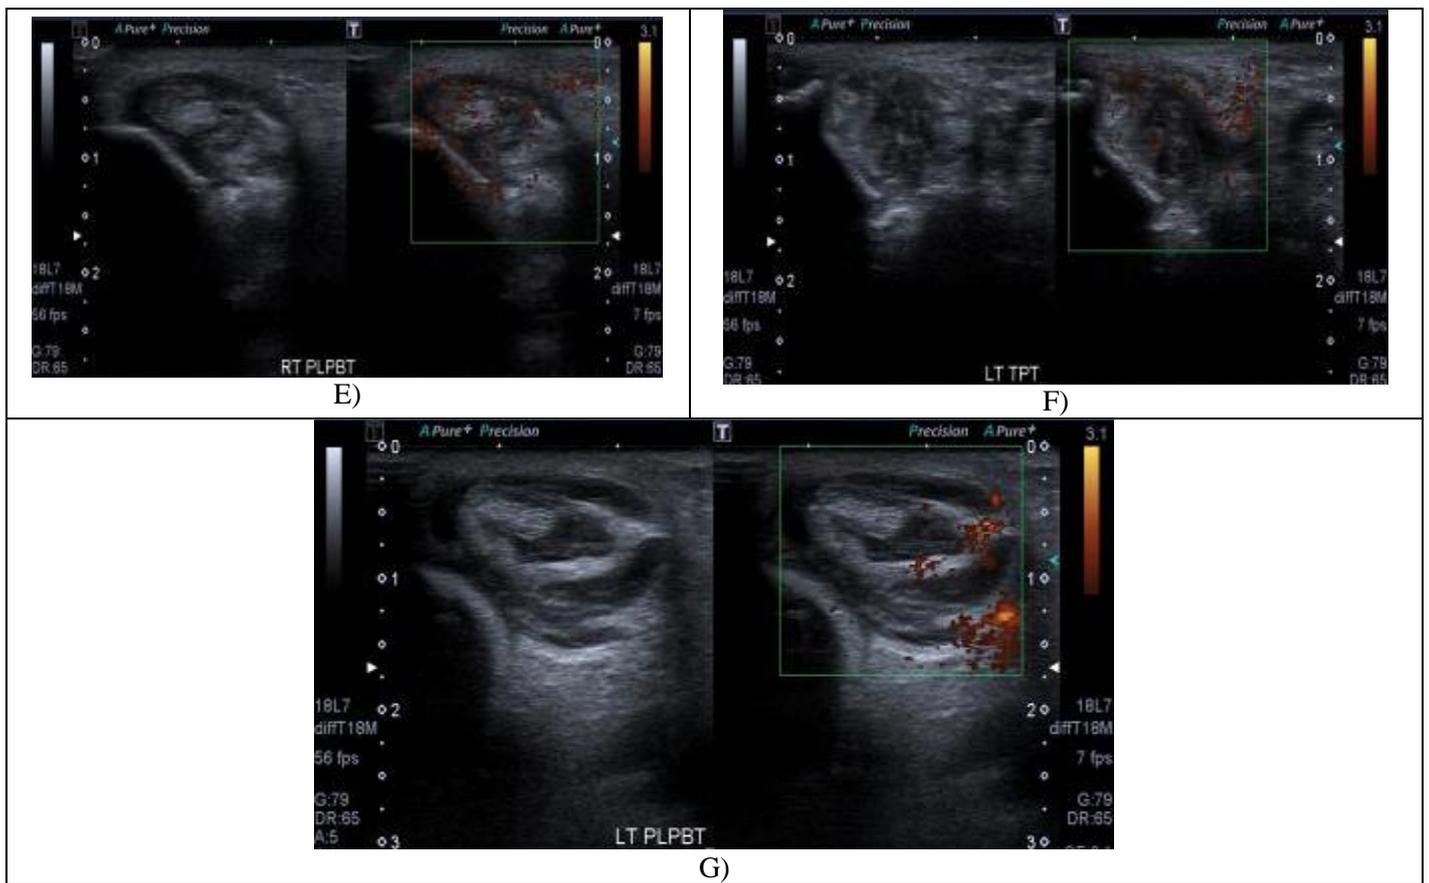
A) GSUS and PDUS of the right tibiotalar joint displaying synovial hypertrophy denoting synovitis. B) GSUS and PDUS of the right talonavicular joint displaying synovial hypertrophy and power Doppler signal denoting synovitis. C) GSUS and PDUS of the right tibialis posterior tendon (short axis) displaying tenosynovitis and power Doppler signal. D) GSUS and PDUS of the right tibialis posterior tendon (long axis) displaying tenosynovitis and power Doppler signal. E) GSUS and PDUS of the right PLBT displaying tenosynovitis and power Doppler signal. F) GSUS and PDUS of the left tibialis posterior tendon displaying tenosynovitis and power Doppler signal. G) GSUS and PDUS of the left PLBT displaying tenosynovitis and power Doppler signal.
